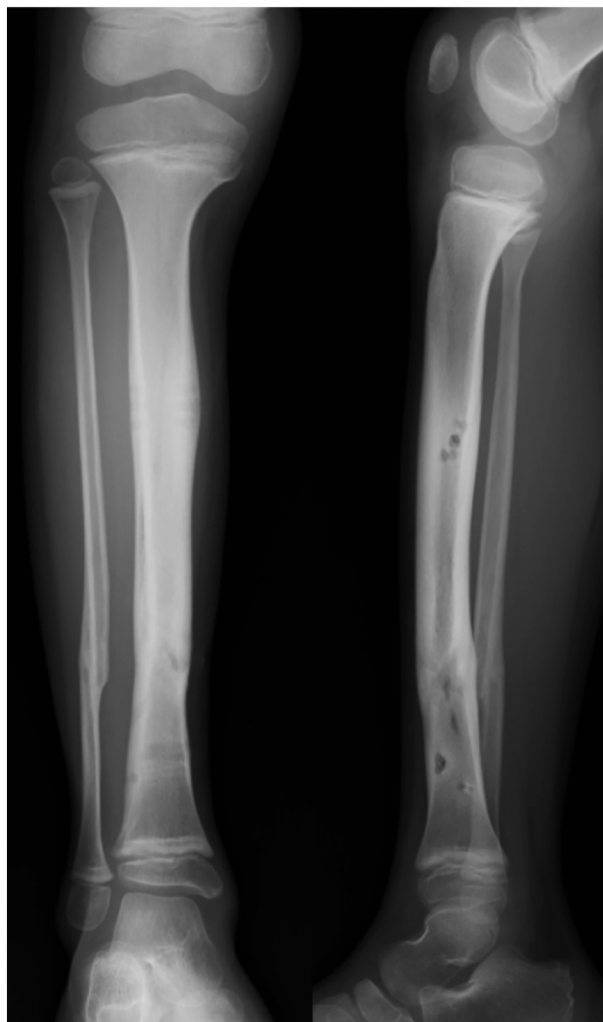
Radiographs show healing of the fracture at 6 months postoperatively.
